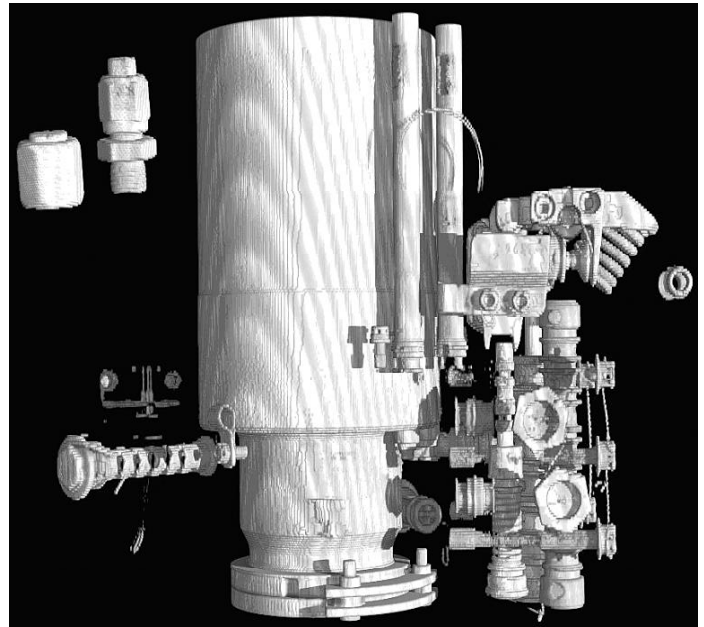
CT image of servoactuator with low-density materials digitally removed.
